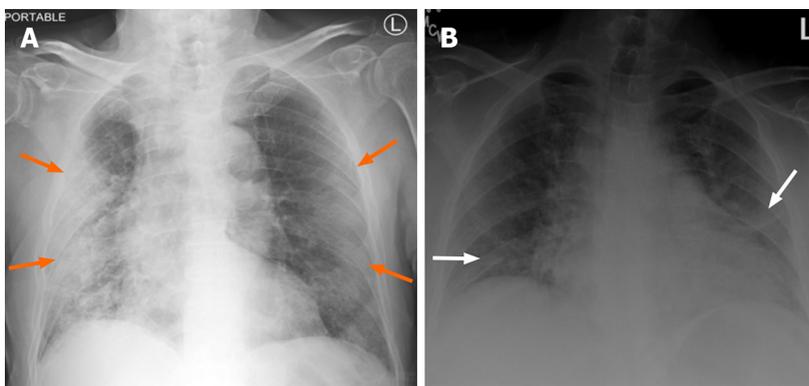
Chest radiography. A: A 62 year old male presented with fever, cough and shortness of breath with coronavirus disease 2019 infection shows large air-space opacities with subpleural and peripheral predominance (orange arrows) in both lungs; B: A 61 years old female came with known cardiomegaly and congestive heart failure presented with cough shows patchy hazy airspace opacities in both lung parenchymas (white arrows).
